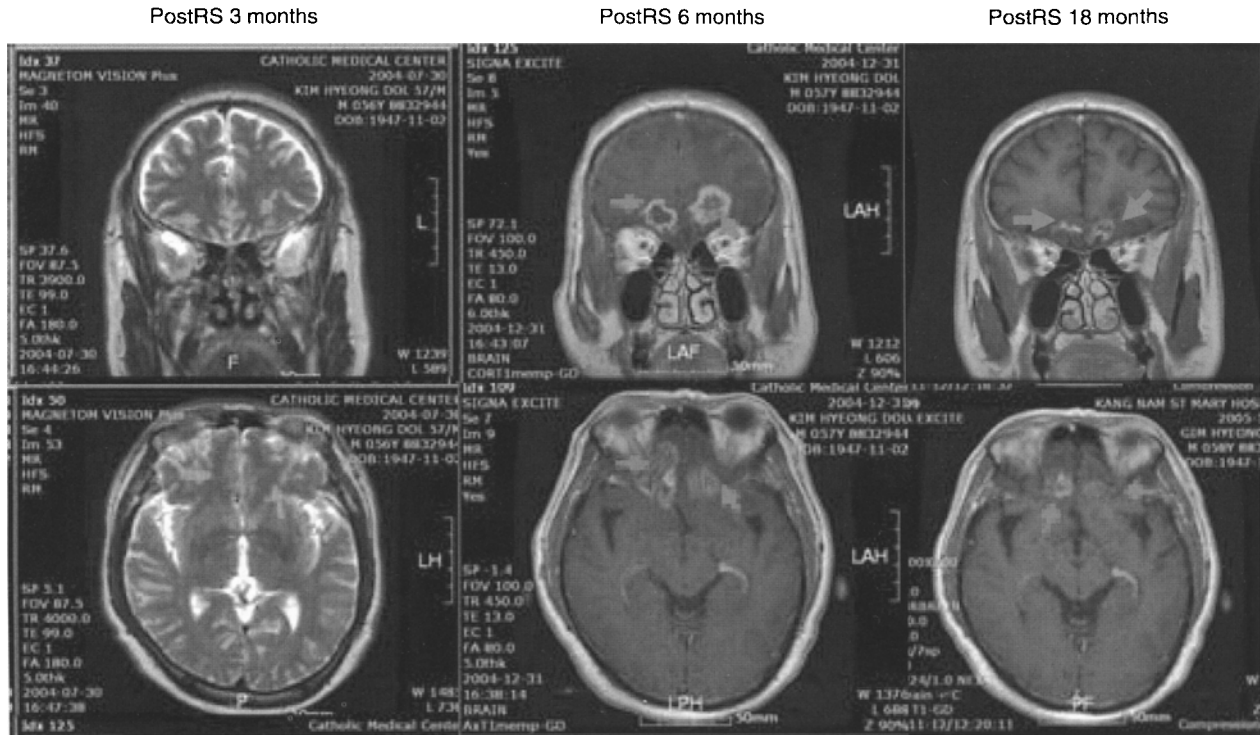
Postoperation MRI in bilateral subcaudate tractomy. Note: MRI shows bilateral radionecrotic change in subcaudate tract area after CKRS
